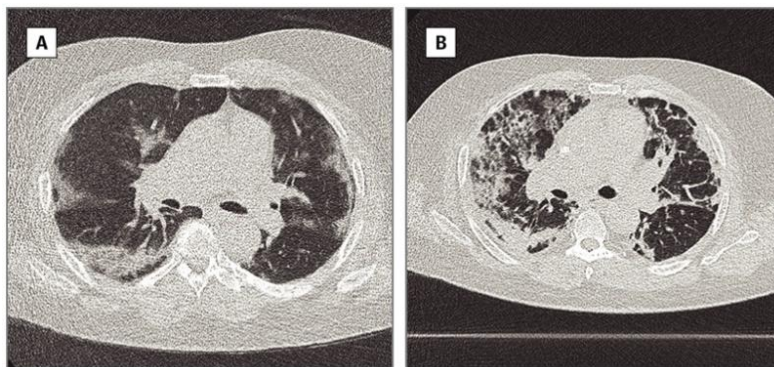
(A) Transverse thin-section CT scan of a 76-years-old man, 5 days after symptom onset, showing subpleural ground-glass opacity and consolidation with subpleural sparing. (B) Transverse thin-section computed tomographic scan of a 76-years-old man, 21 days after symptom onset, showing bilateral and peripheral predominant consolidation, ground-glass with reticulation, and bronchodilatation. Adapted from (156).
